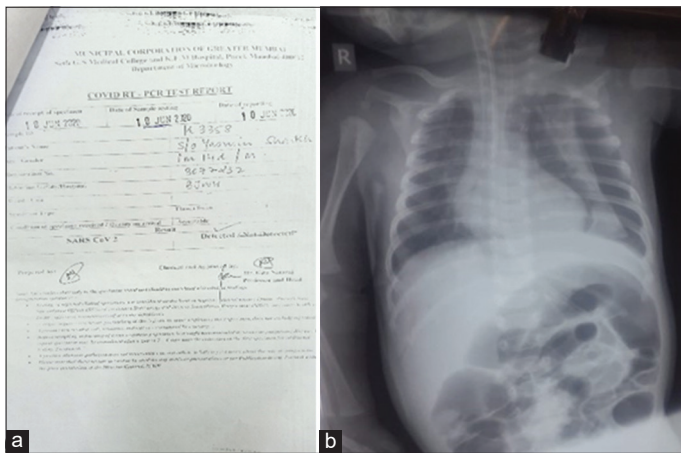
(a) RT-PCR report and (b) chest X-ray of the patient
